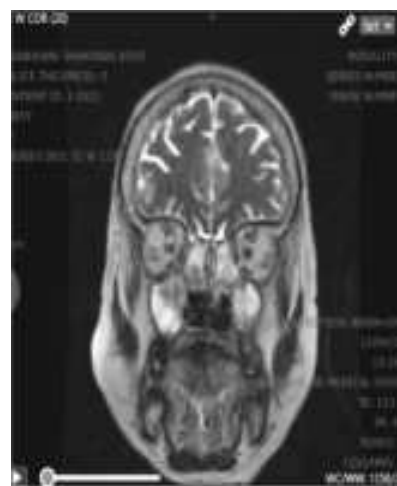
MRI showing bilateral involvement of paranasal sinuses
